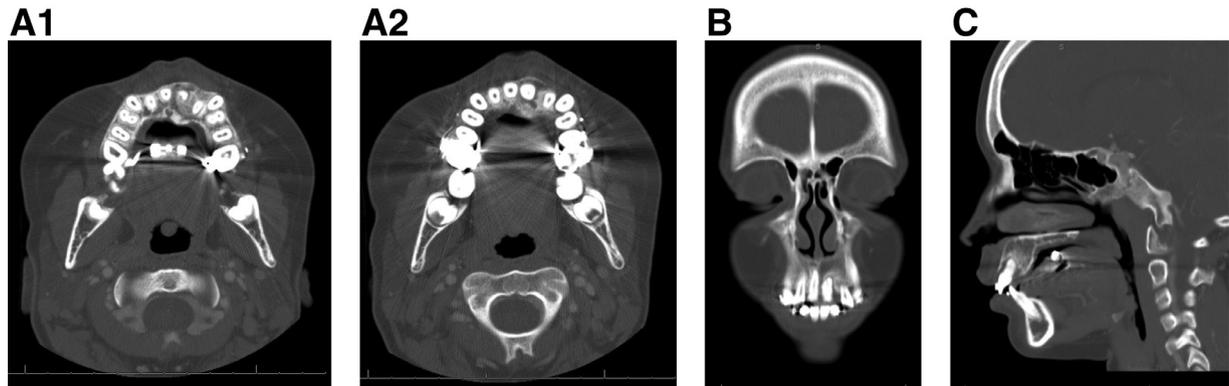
Facial computed tomography (CT) scan obtained before initial biopsy. (A) Axial views. (B) Coronal view. (C) Sagittal view. Thin, irregularly shaped hypodensity surrounds resorbed root of tooth #9 with adjacent sclerosis as well as mild buccal and palatal expansion.
